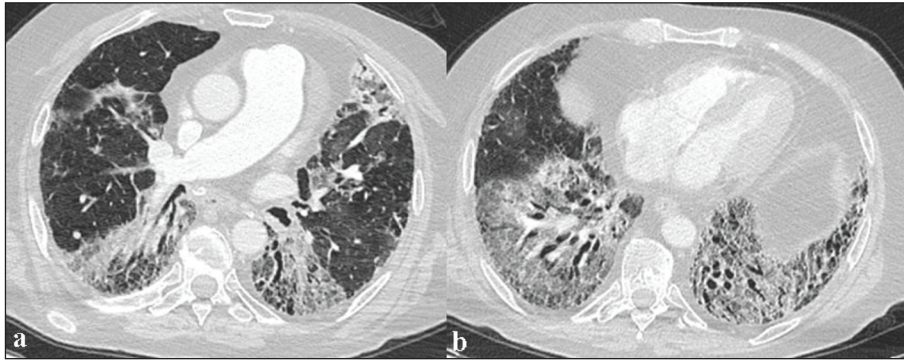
a, b) Fibrosis and ground glass appearance (parenchymal window) in the lower lobes on thorax CT
